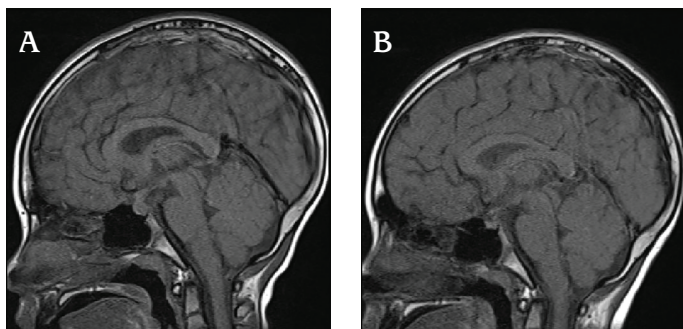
(A, B) Pre- and posttreatment magnetic resonance images of the 8-year-old boy
